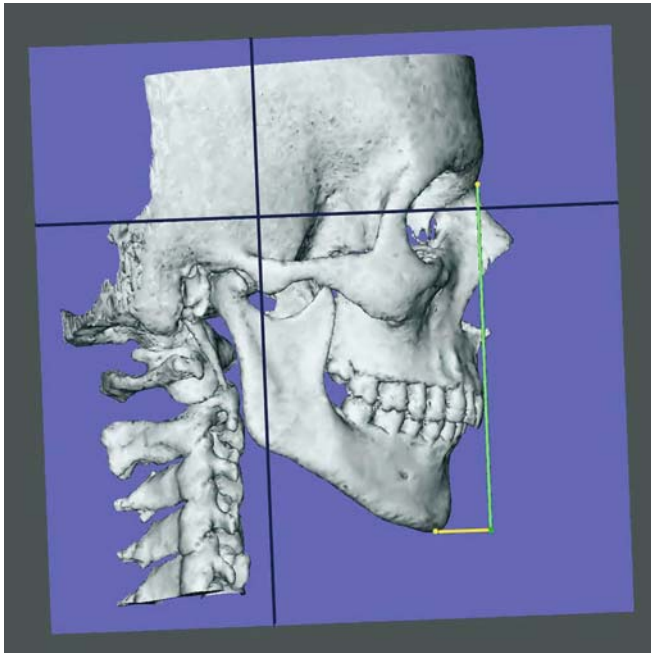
Anterior total facial height, N-Men (3-D CT, hard tissues, patient K.C.)
